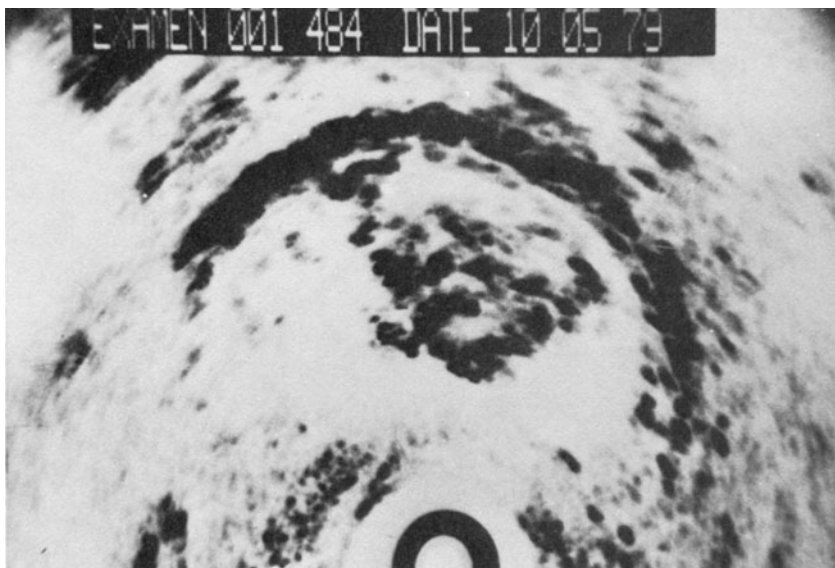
Strong internal mass echoes and unevenness in capsule thickness suggest prostatic cancer in this sonogram of a T2 prostatic cancer.
